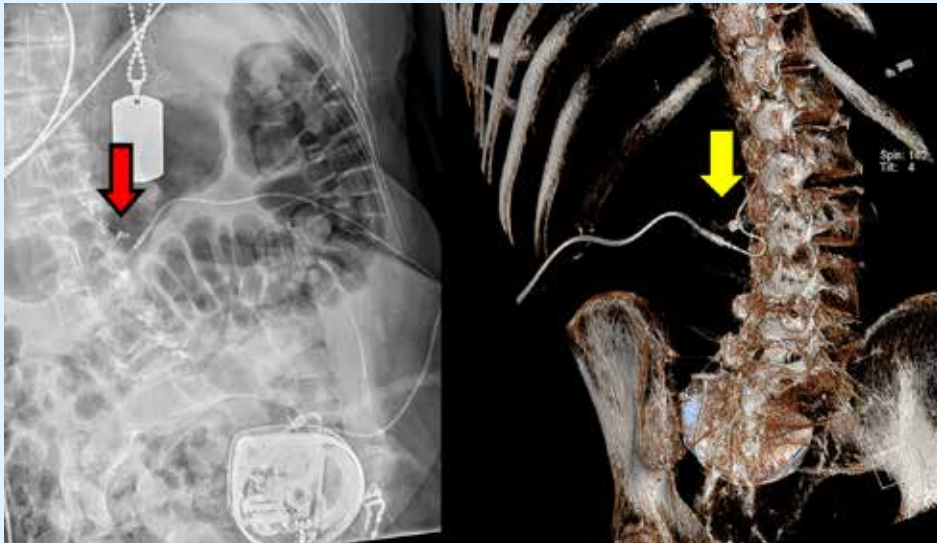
Improved catheter visualization. Plain radiography indicated a possible kinked catheter (red arrow). DECT with 3D volume rendering revealed a regular curved catheter (yellow arrow) with no obstruction.
